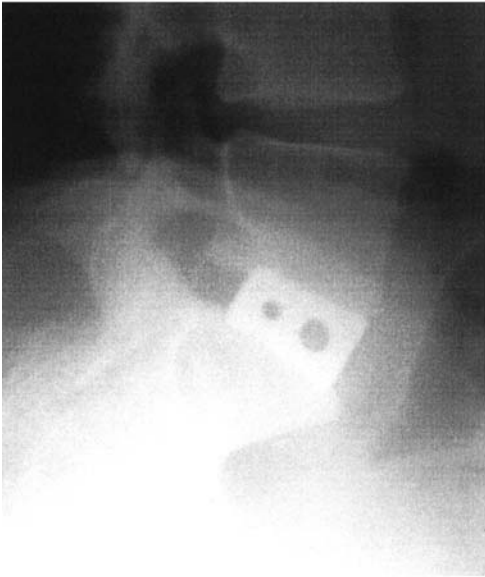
(A) Lateral radiograph shows disc space collapse at the L5–S1 interspace. (B) Anteroposterior and (C) lateral radiographs after surgery show the cylindrical titanium cages centrally placed in the L5–S1 disc space. Normal disc space height and lordosis have been restored. The implants have been reamed 3 mm into each vertebral end plate. The self-tapping threads of the implant form a secure interface with the host bone of the adjacent vertebra.
